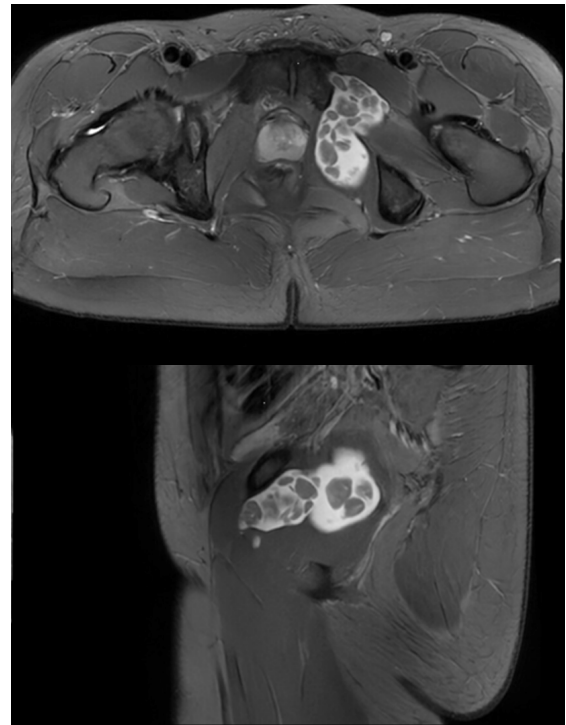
Coronal (Top) and sagittal (Bottom) T2-weighted pelvic MRI images show a well-circumscribed multicystic mass. The mass is hyperintense on T2 with multiple small bodies which are less intense than the surrounding fluid. The mass involves the left obturator internus as well as the obturator externus and the adductor compartment.
